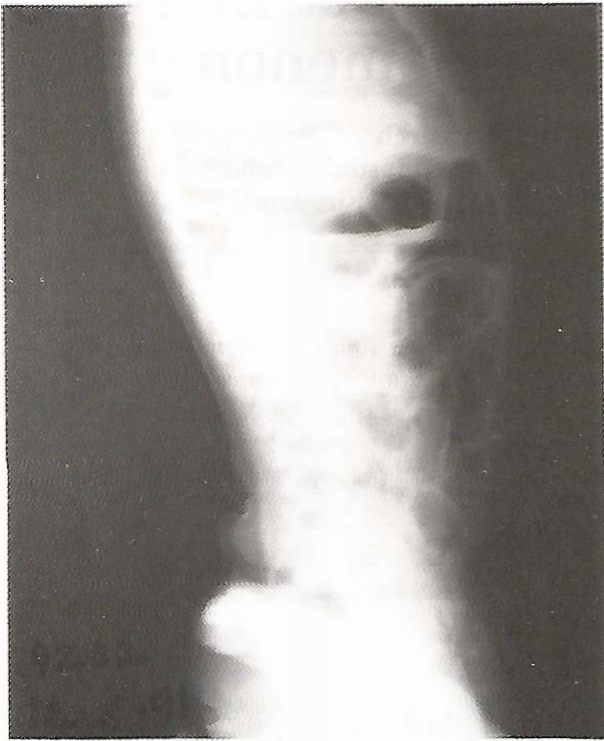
X-ray chest (lateral view).
